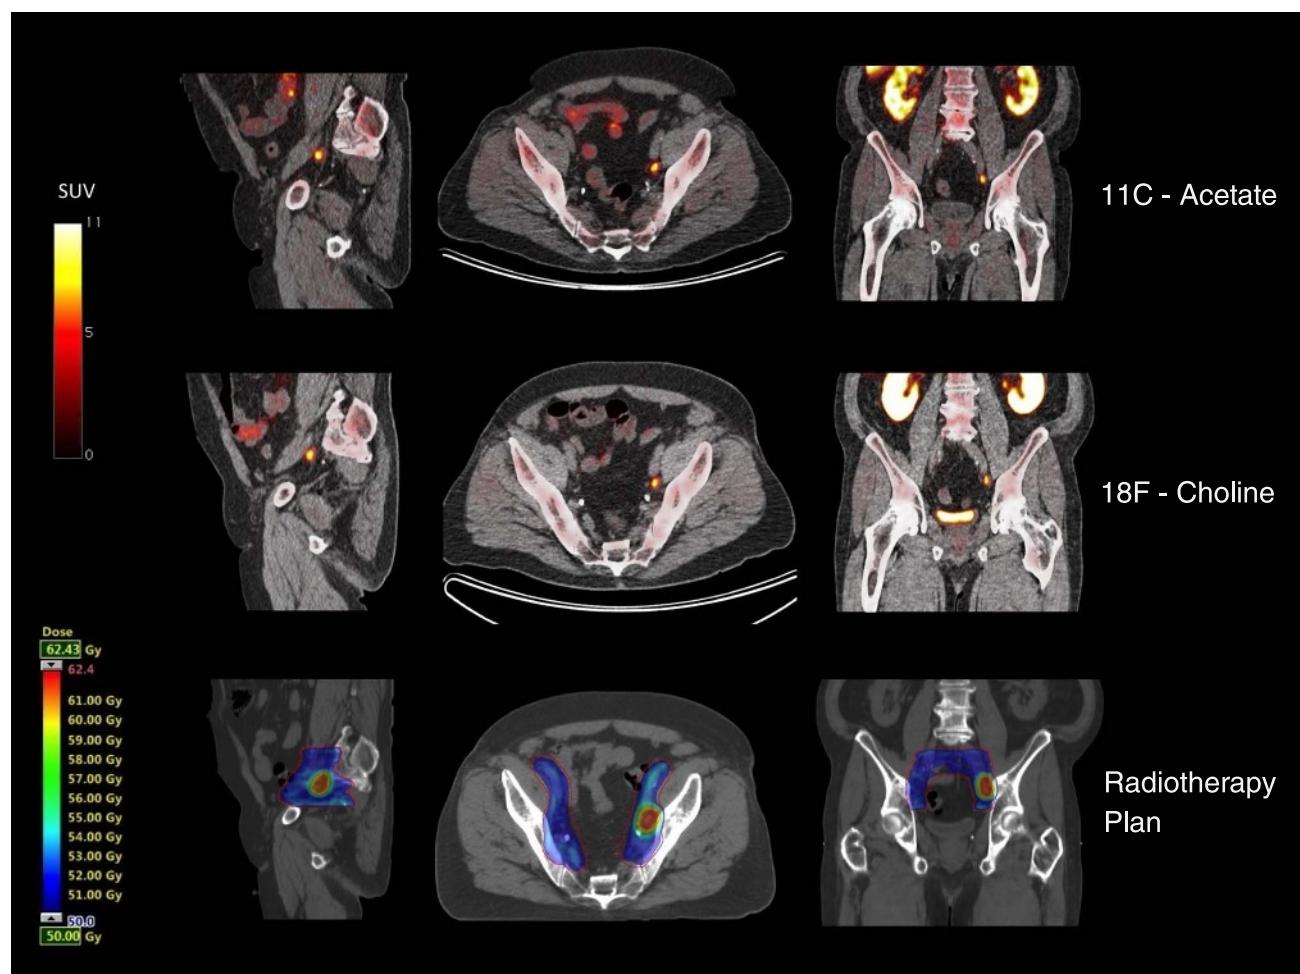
PET-CT images representing an ¹¹C-ACE- and ¹⁸F-FCH-positive pelvic lymph node in a 63-year-old man with biochemical relapse (PSA 4 ng/mL) after definitive RT and the color-wash dose distribution of the subsequent image-guided salvage RT plan.
